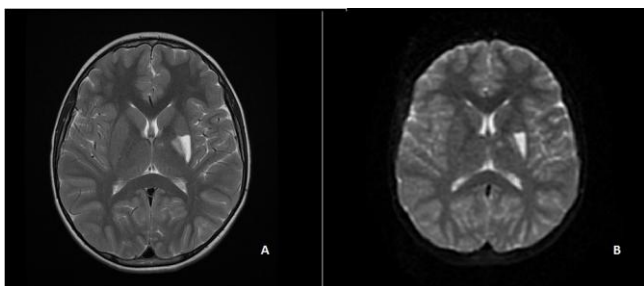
The cerebral MRI showing a hyperintense lesion at the left putamen and globus pallidus interna and externa on T2 (A) and diffusion weighted images (B)
